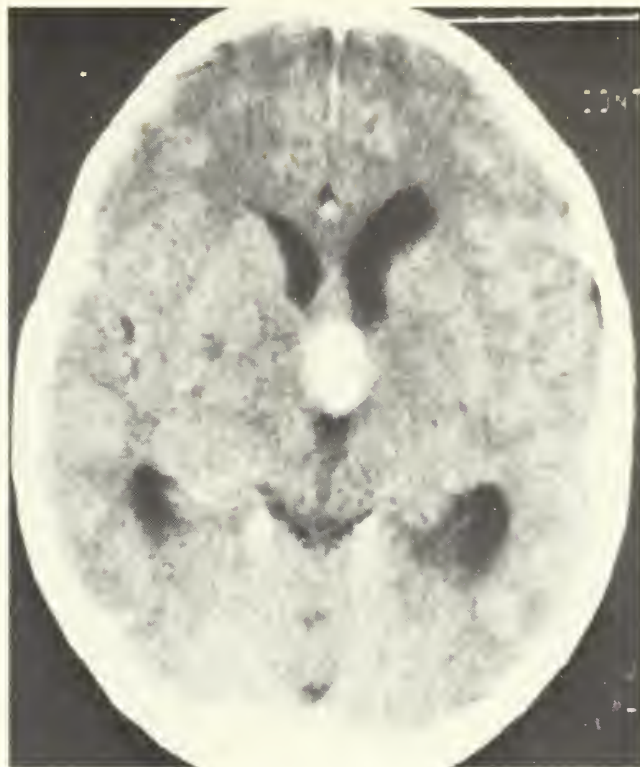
CT scan showing an enhancing suprasellar mass causing obstruction of CSF flow. Presumptive diagnosis is optic chiasmal glioma.
